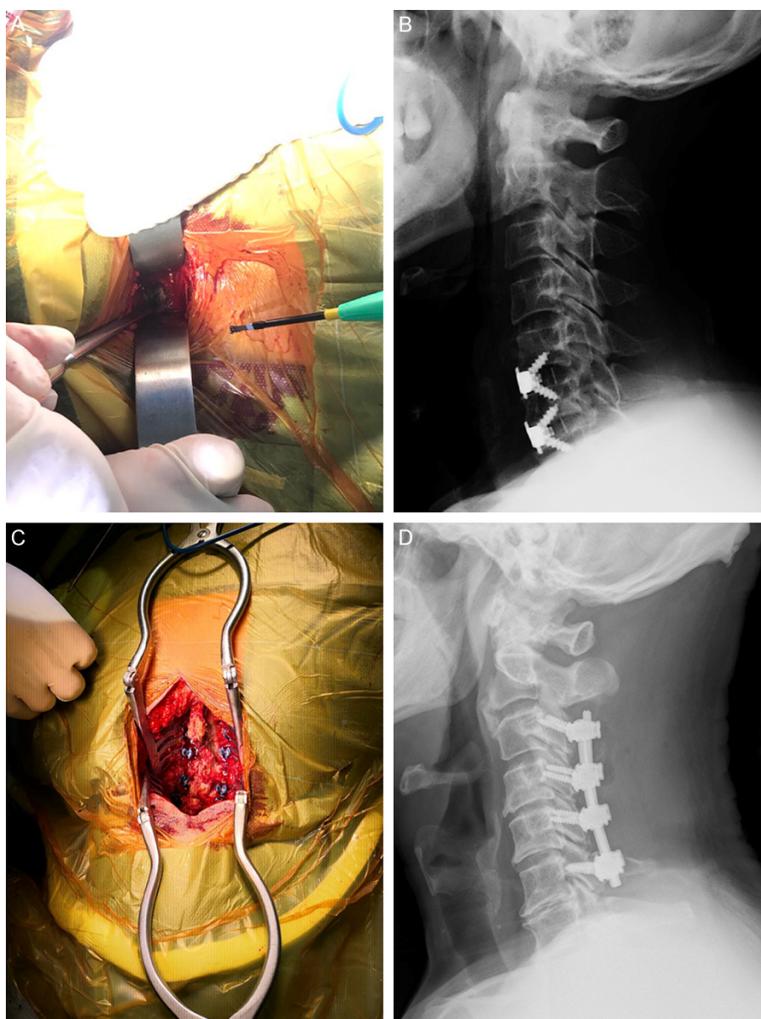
A 60-year-old male patients with cervical spondylotic myelopathy who received anterior cervical surgery (A: Surgical photo; B: X-ray after surgery); A 58-year-old male patients with cervical spondylotic myelopathy who received posterior cervical surgery (C: Surgical photo; D: X-ray after surgery).
